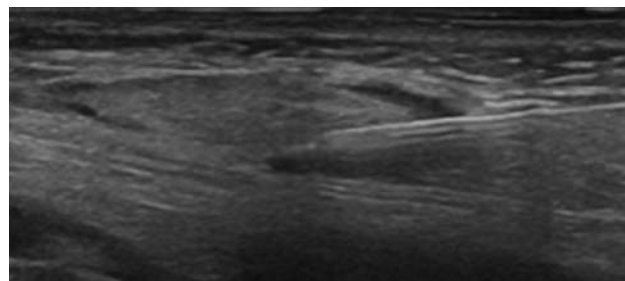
Ultrasound-guided lymph node puncture. A 25- to 22-gauge needle is placed into the center of a lymph node for contrast application.
